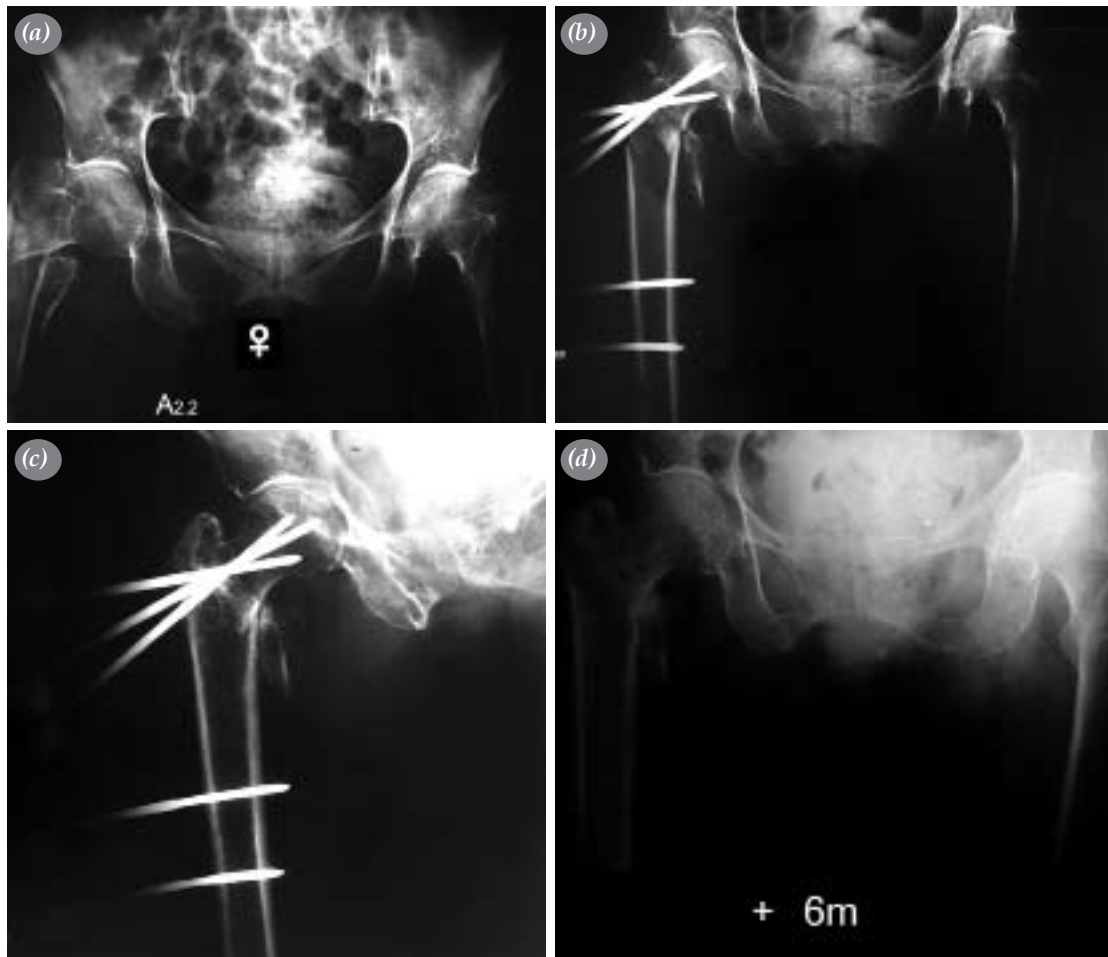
(a) Anteroposterior radiograph of a seventy-three year old woman who sustained a A2.2 type intertrochanteric fracture as a result of a fall at home. (b) Postoperative radiographs of the same patient shows satisfactory fracture reduction (c) anteroposterior radiograph 3 months after the operation (d) anteroposterior radiograph 6 months after the operation
